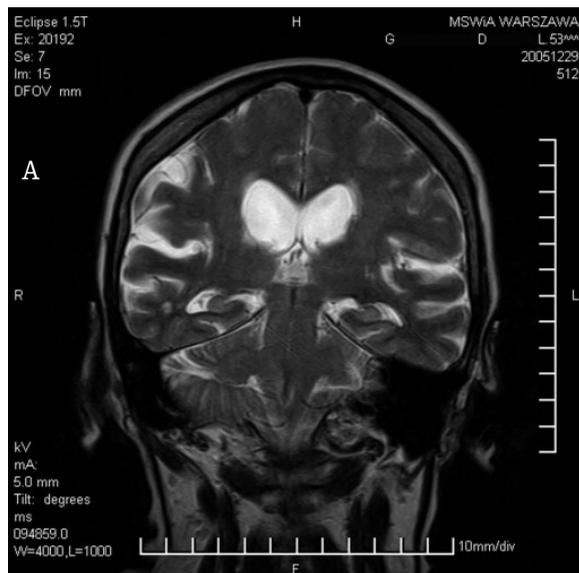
a, b. 61 year-old woman with 14 year history of SSc and TIAs (episodic left hemiparesis and dysphasia). MRI, FSE, T2-weighted and FLAIR images: mild atrophy with ventricular enlargement, vasogenic scar in right parietotemporal region, multiple focal lesions in periventricular, deep and subcortical location.
